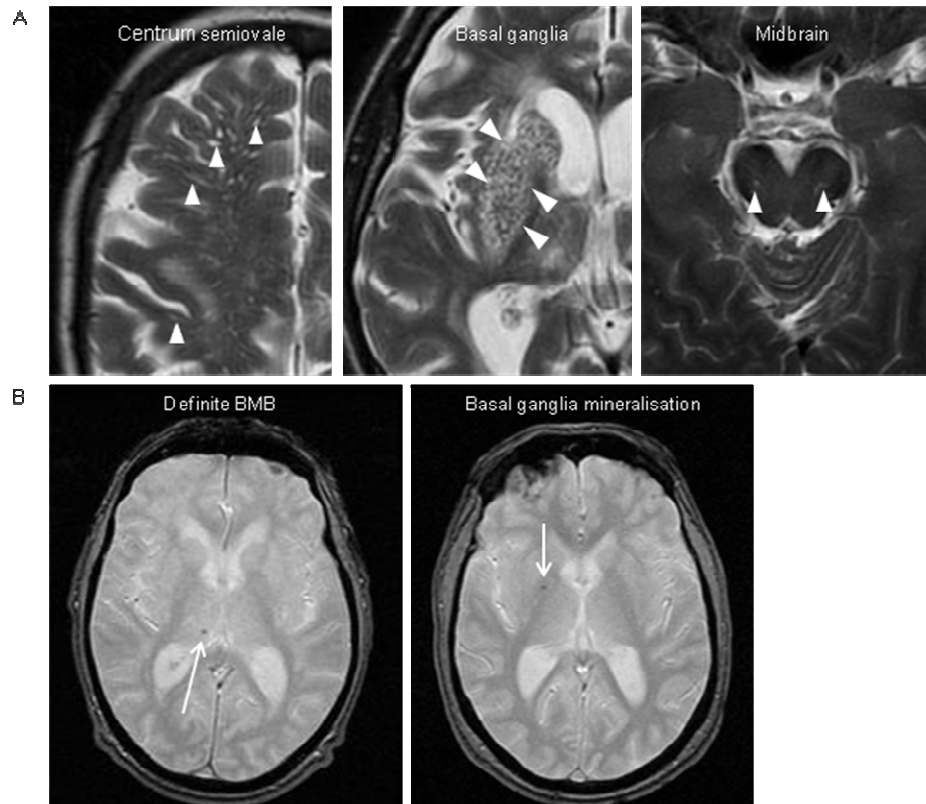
Axial brain MRI showing enlarged perivascular spaces (EPVS) and brain microbleeds (BMB)
